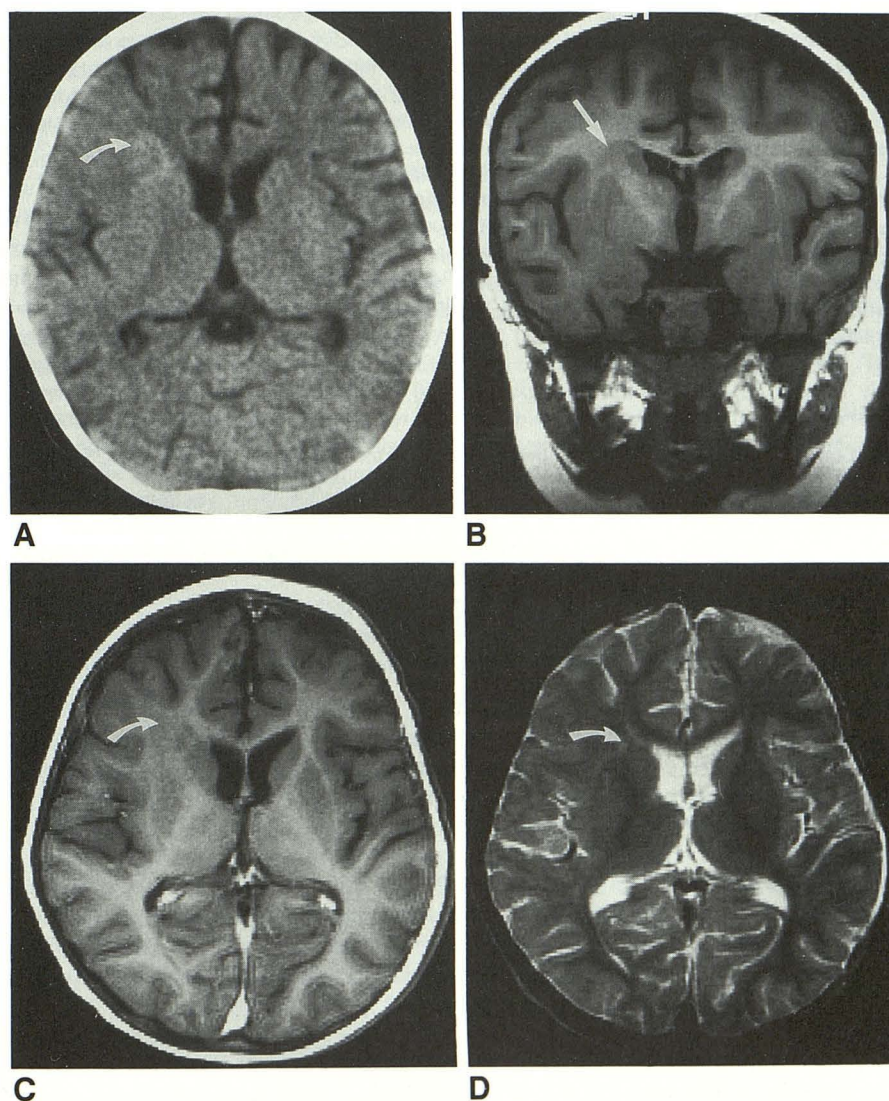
A, Noncontrast CT scan shows vague area of increased attenuation adjacent to head of right caudate nucleus (arrow).
